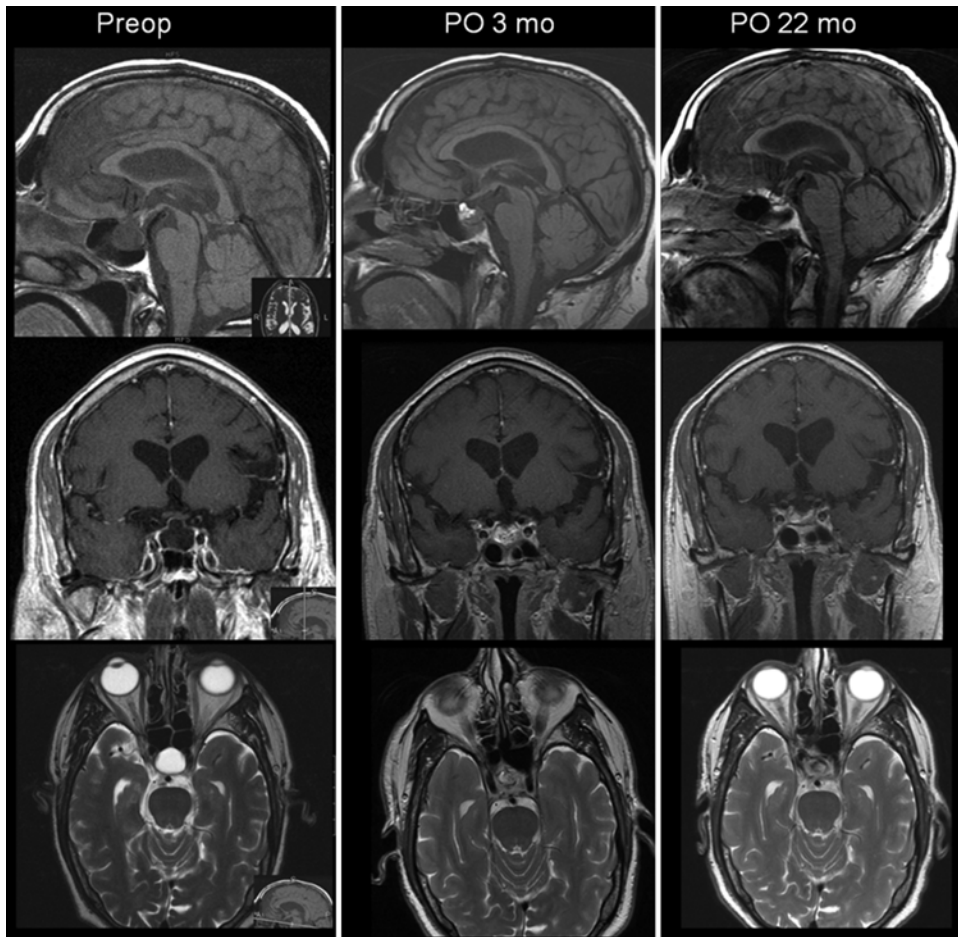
Case 4. Sagittal (upper row), coronal (center row), and axial (lower row) MR images showing rapid fat resorption. Preoperative imaging (left column) shows an intrasellar AC with suprasellar extension. Postoperative imaging at 3 (center column) and 22 months (right column) shows progressive fat tissue resorption but no recurrence of the cystic cavity.
